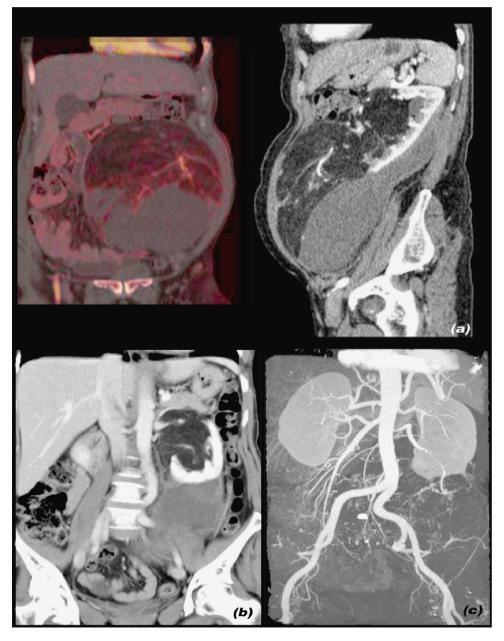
Preoperative computed tomography scan (a,b) showing the presence of a mass origining from the inferior pole of the left kidney and angiography (c) showing a double left renal artery.
